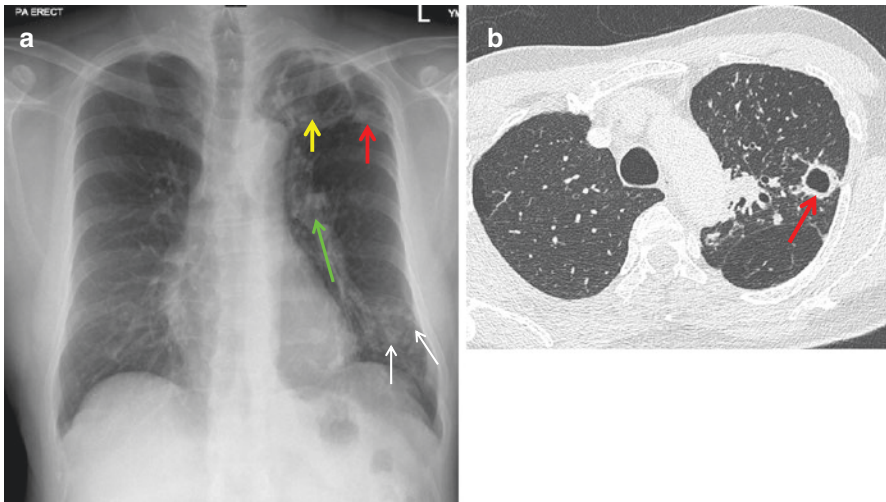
(a) Chest radiograph with a left apical thin-walled cavity (yellow arrow) with an adjacent small opacity (red arrow). Further nodular shadows in the left lower zone (white arrows). Left hilar elevation (green arrow) in keeping with left upper lobe volume loss. (b) Axial CT slice of a follow-up CT thorax inferior to the level of the large radiographically visible apical cavity. This shows the subjacent nodule is also cavitory in nature. Surrounding centrilobular nodularity is also noted
